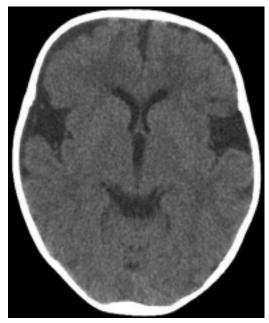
Postoperative CT scan obtained at the 11-month followup examination, demonstrating resolution of the subdural collections. There is persistent prominent extraaxial fluid in both sylvian fissures.
